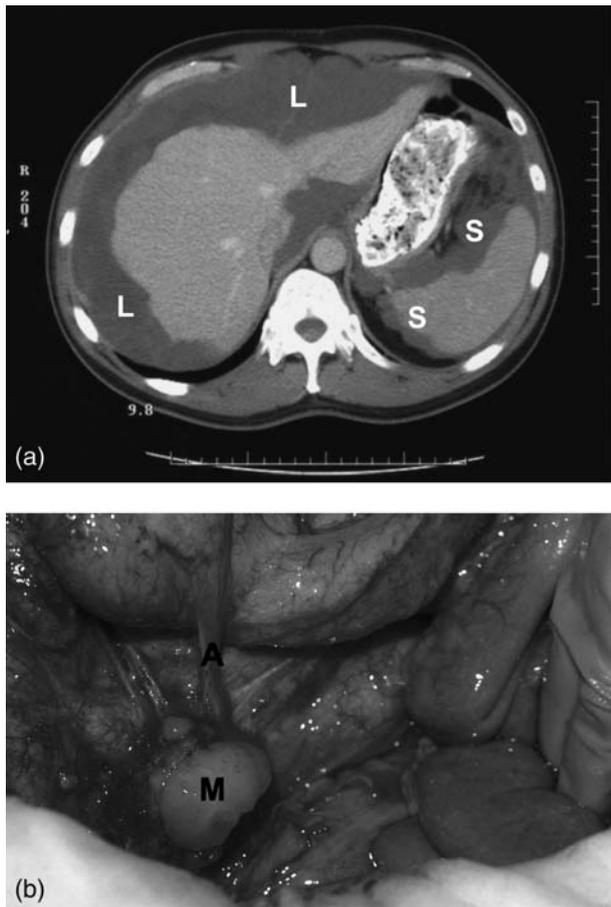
(a) Computed tomography (CT) scan demonstrating classical appearance of advanced Pseudomyxoma peritonei: scalloping of liver (L) and involvement of spleen (S). (b) large appendiceal mucocele (M) and appendix (A).
